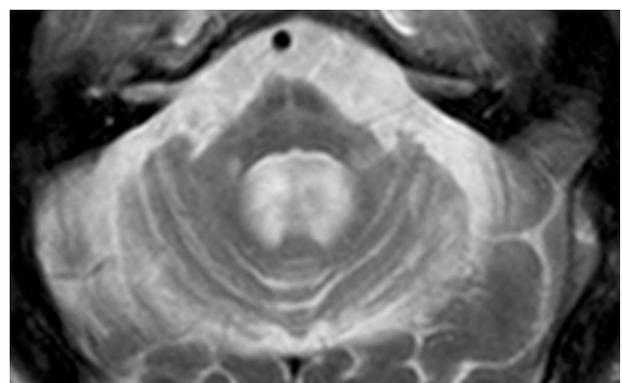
T2-weighted MRI of the cerebellum (axial view) in a patient with multiple system atrophy cerebellar type, showing cerebellar and pontine atrophy and the hot cross bun sign in the pons.
